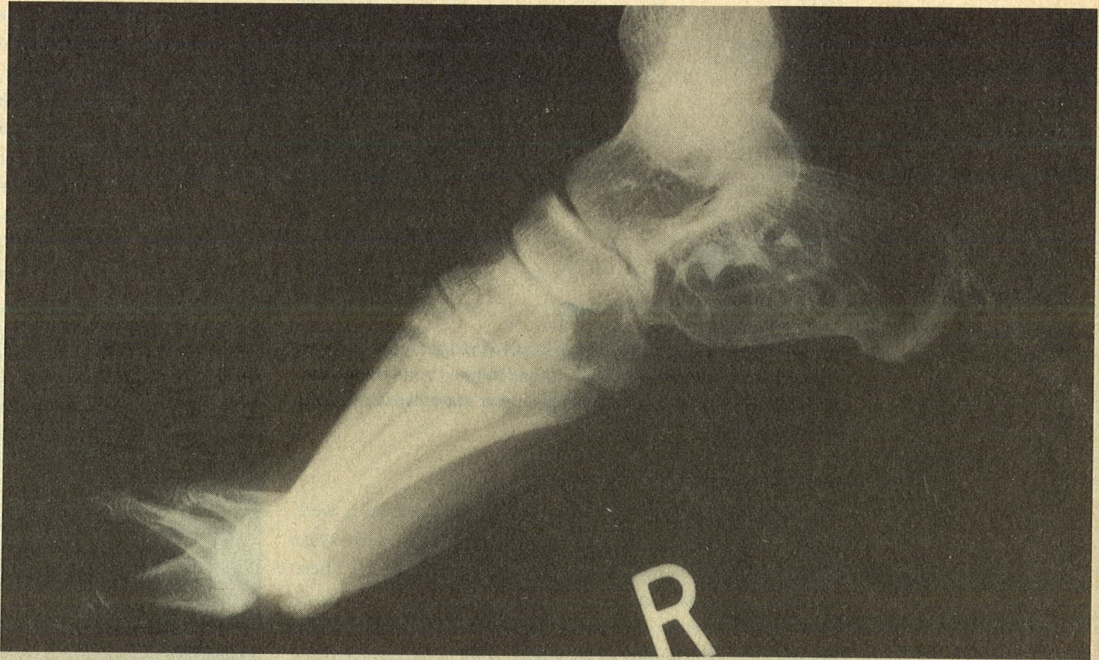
Lateral radiograph of the right foot and ankle
